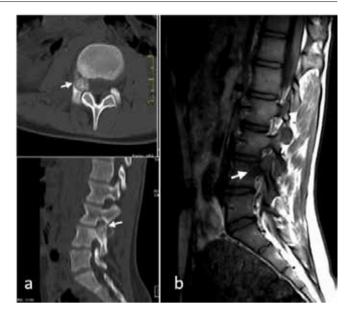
a) axial and sagittal CT sections and b) MRI sagittal view of the lumbar spine showing a mass lesion in the right peduncle of L4 vertebrae
